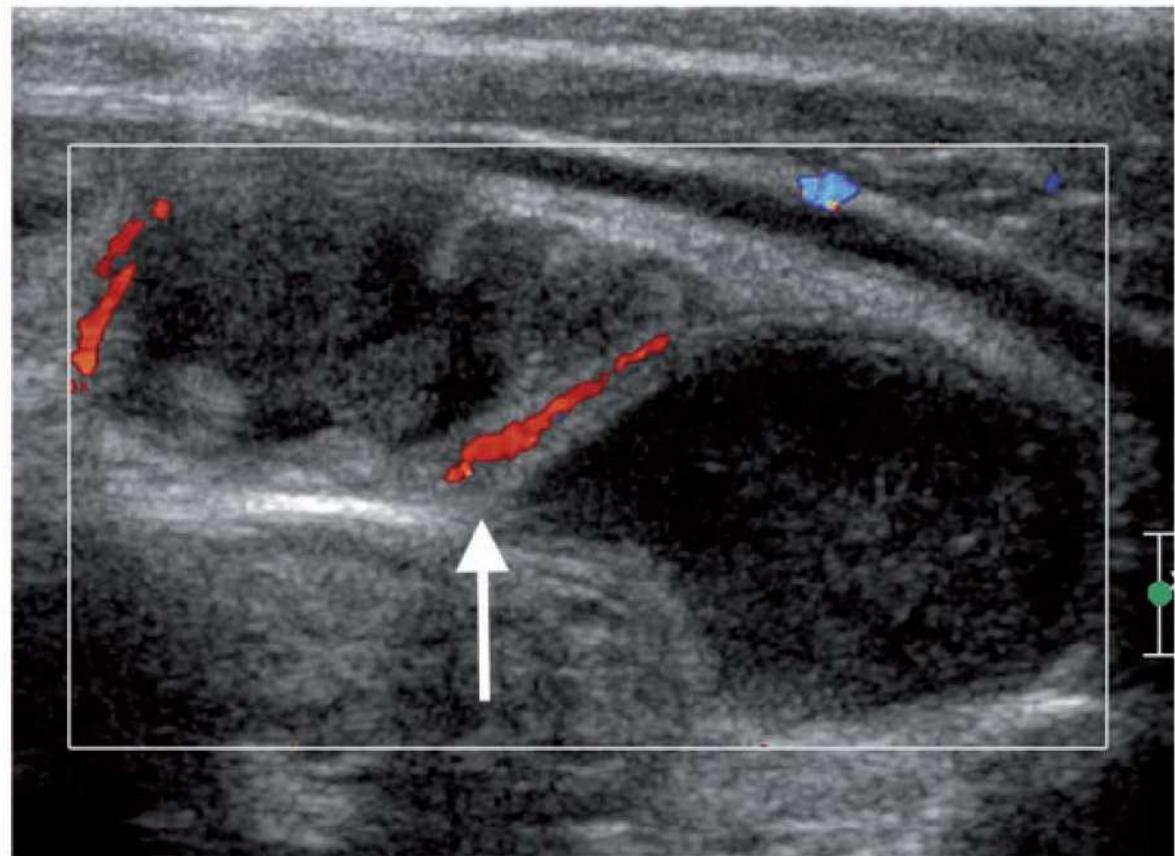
Ultrasonographic appearances of normal bowel. This nine-year-old girl presented with abdominal pain. (a) US of the bowel loops (arrow) showed no mural thickening, increased echogenicity or intramural gas. Mural thickness in a loop of bowel is better assessed when it contains hypoechoic fluid as shown. (b) Preserved bowel perfusion was demonstrated (arrow). Bowel peristalsis was observed under real-time ultrasound.
